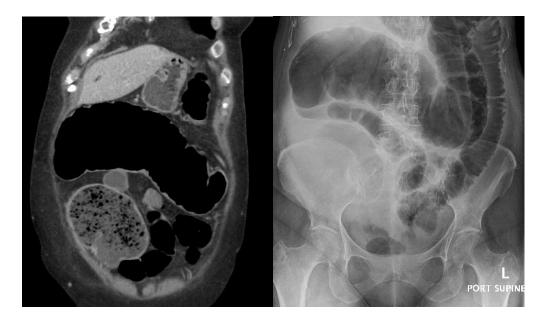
Coronal contrast enhanced CT showed pancolonic thickening, dilatation to 8.1cm and abnormal enhancement most in keeping with an inflammatory or infectious pancolitis (A). Two days later, an abdominal radiograph showed pancolonic dilation up to 10.5cm with possible pneumatosis (B).
